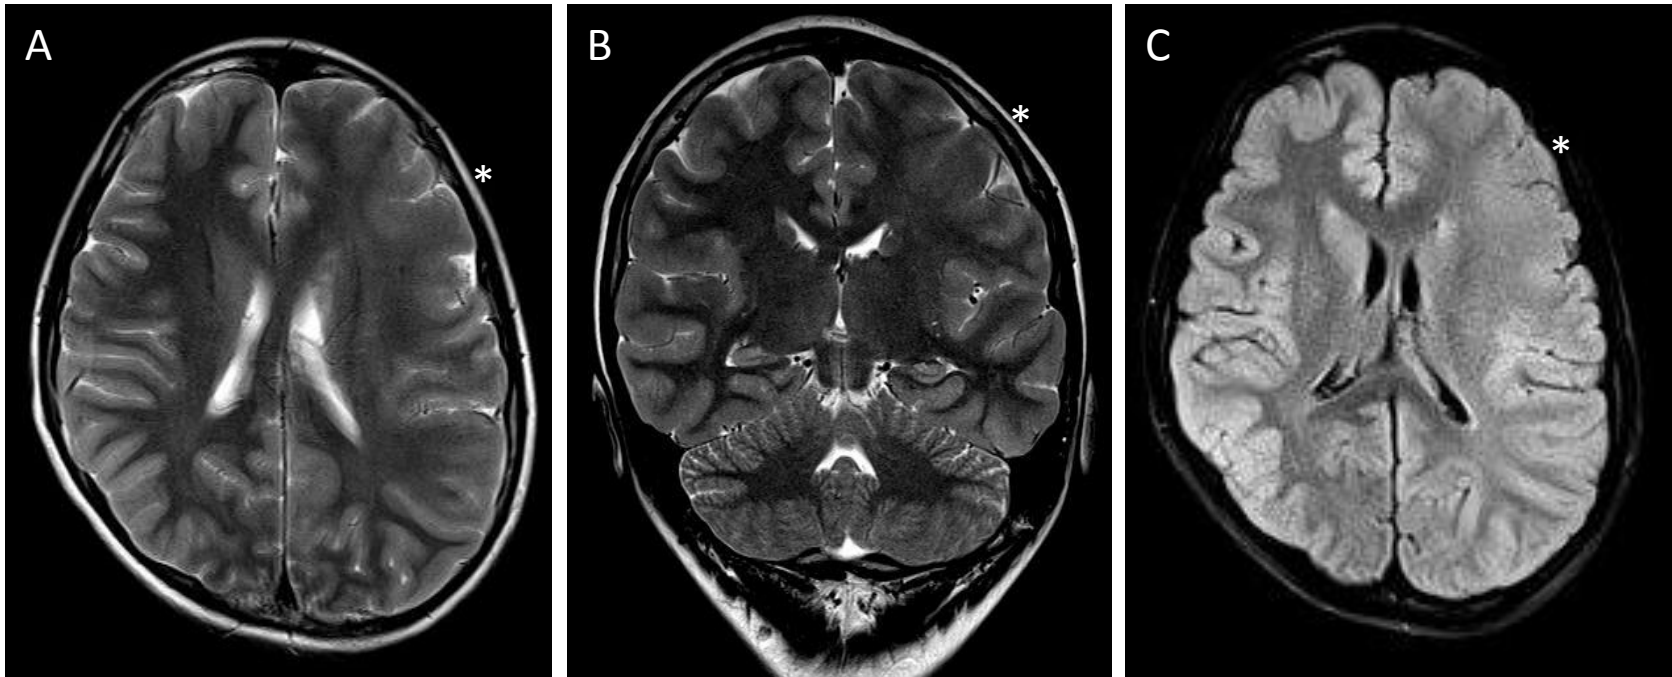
Extended gray matter type focal cortical dysplasia in a 13-year-old girl. (A) Axial and (B) coronal T2-weighted images show a blurring of the gray-white matter junction with severely involved cortex in the left frontal lobe. (C) Axial FLAIR image shows mild hyperintense signal changes in the lesion.
